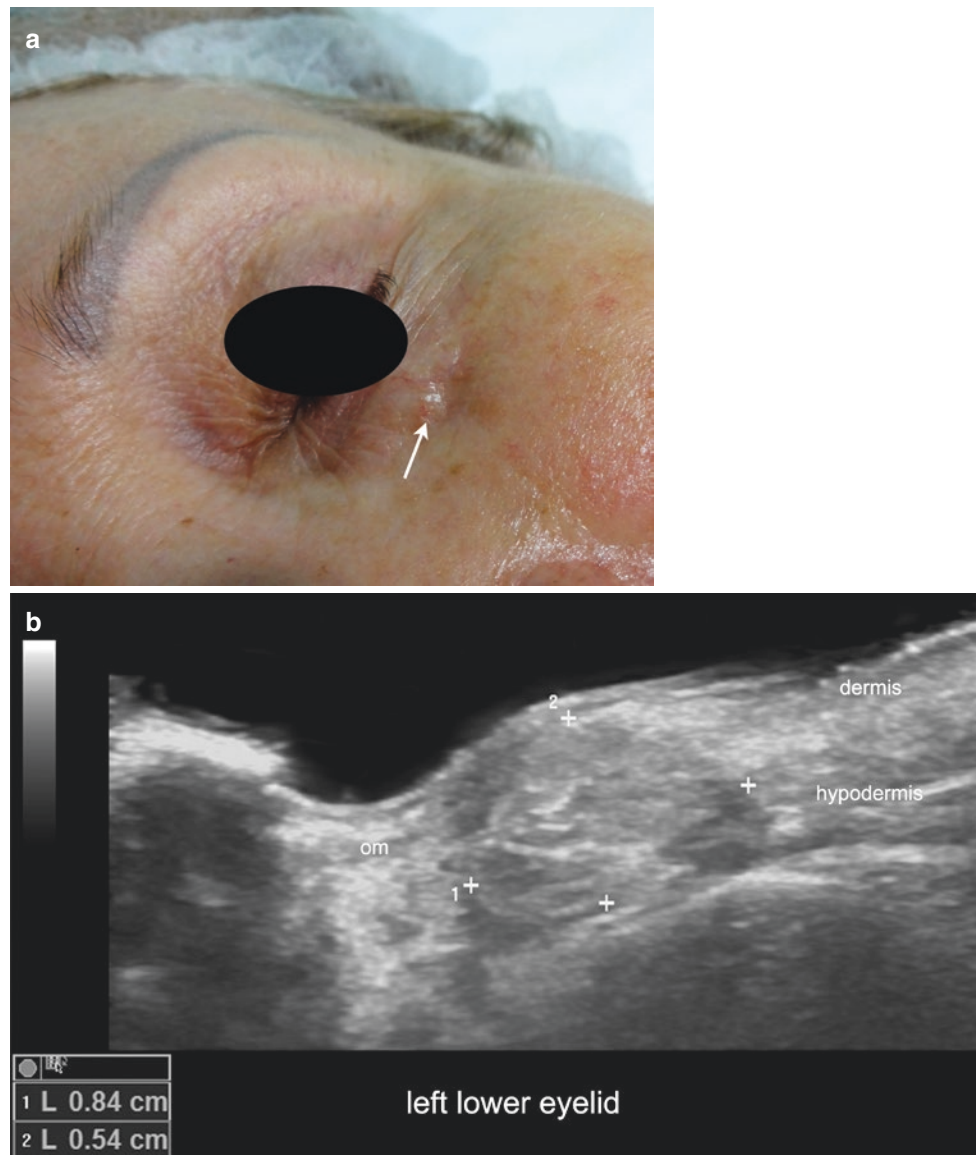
Autologous fat grafting. (a) Clinical image of a patient injected with autologous fat in the lower eyelid, showing a palpable lump (arrow). (b) Ultrasound (greyscale, longitudinal view; left lower
